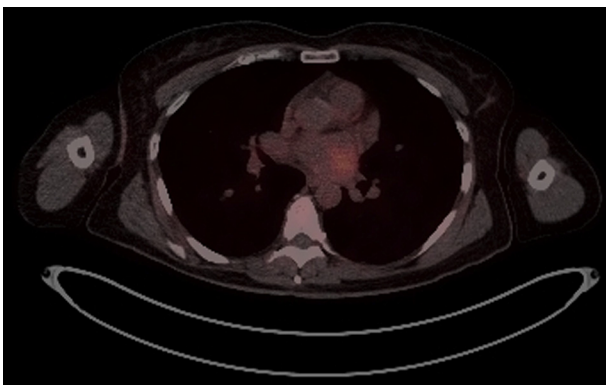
Positron emission tomography/computed tomography tumor imaging with Gallium-68 Dotatate, 5.4 mCi showing abnormal tracer localization corresponds to the known left atrial mass. This finding is most compatible with somatostatin receptor-rich lesions, e.g., cardiac carcinoid.
